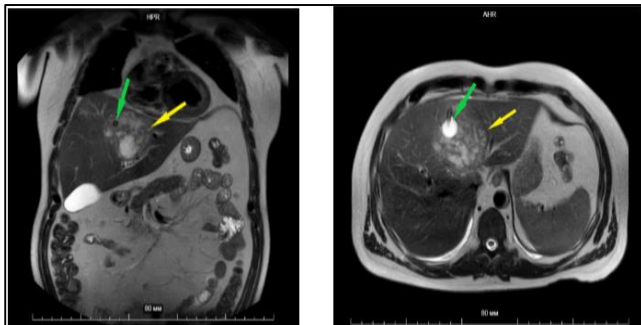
Abdominal MRI (control on the 6th day after surgery). Abscess reduced in size (yellow arrow), drainage tube of catheter with balloon can be seen in its cavity (green arrows).
